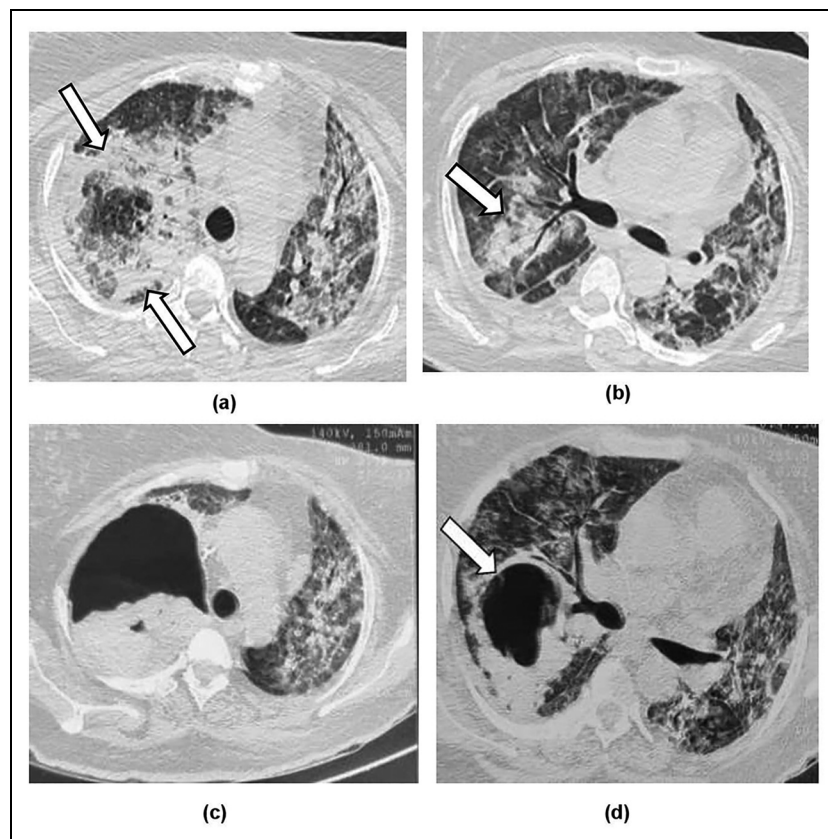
The CT chest of a 48-year-old diabetic female with COVID-19 pneumonia, (a) CT images of cranial section showing rounded area of consolidation in the form of reverse halo or bird's nest appearance (arrows). (b) Section just below the carina shows patchy consolidation patch (arrow). (c, d) Corresponding sections showing development of cavitation at the interval of 3 weeks. Mycological tests of the patients were suggestive of CAPA. Abbreviations: CT, computed tomography; CAPA, COVID-19 associated pulmonary aspergillosis.
